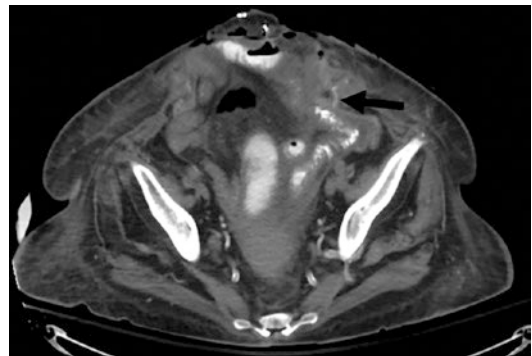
A CT scan obtained on postoperative day 10 following emergent repair of an incarcerated ventral hernia with biologic mesh showing localized contrast extravasation from a non-healed serosal tear that was repaired during surgery
